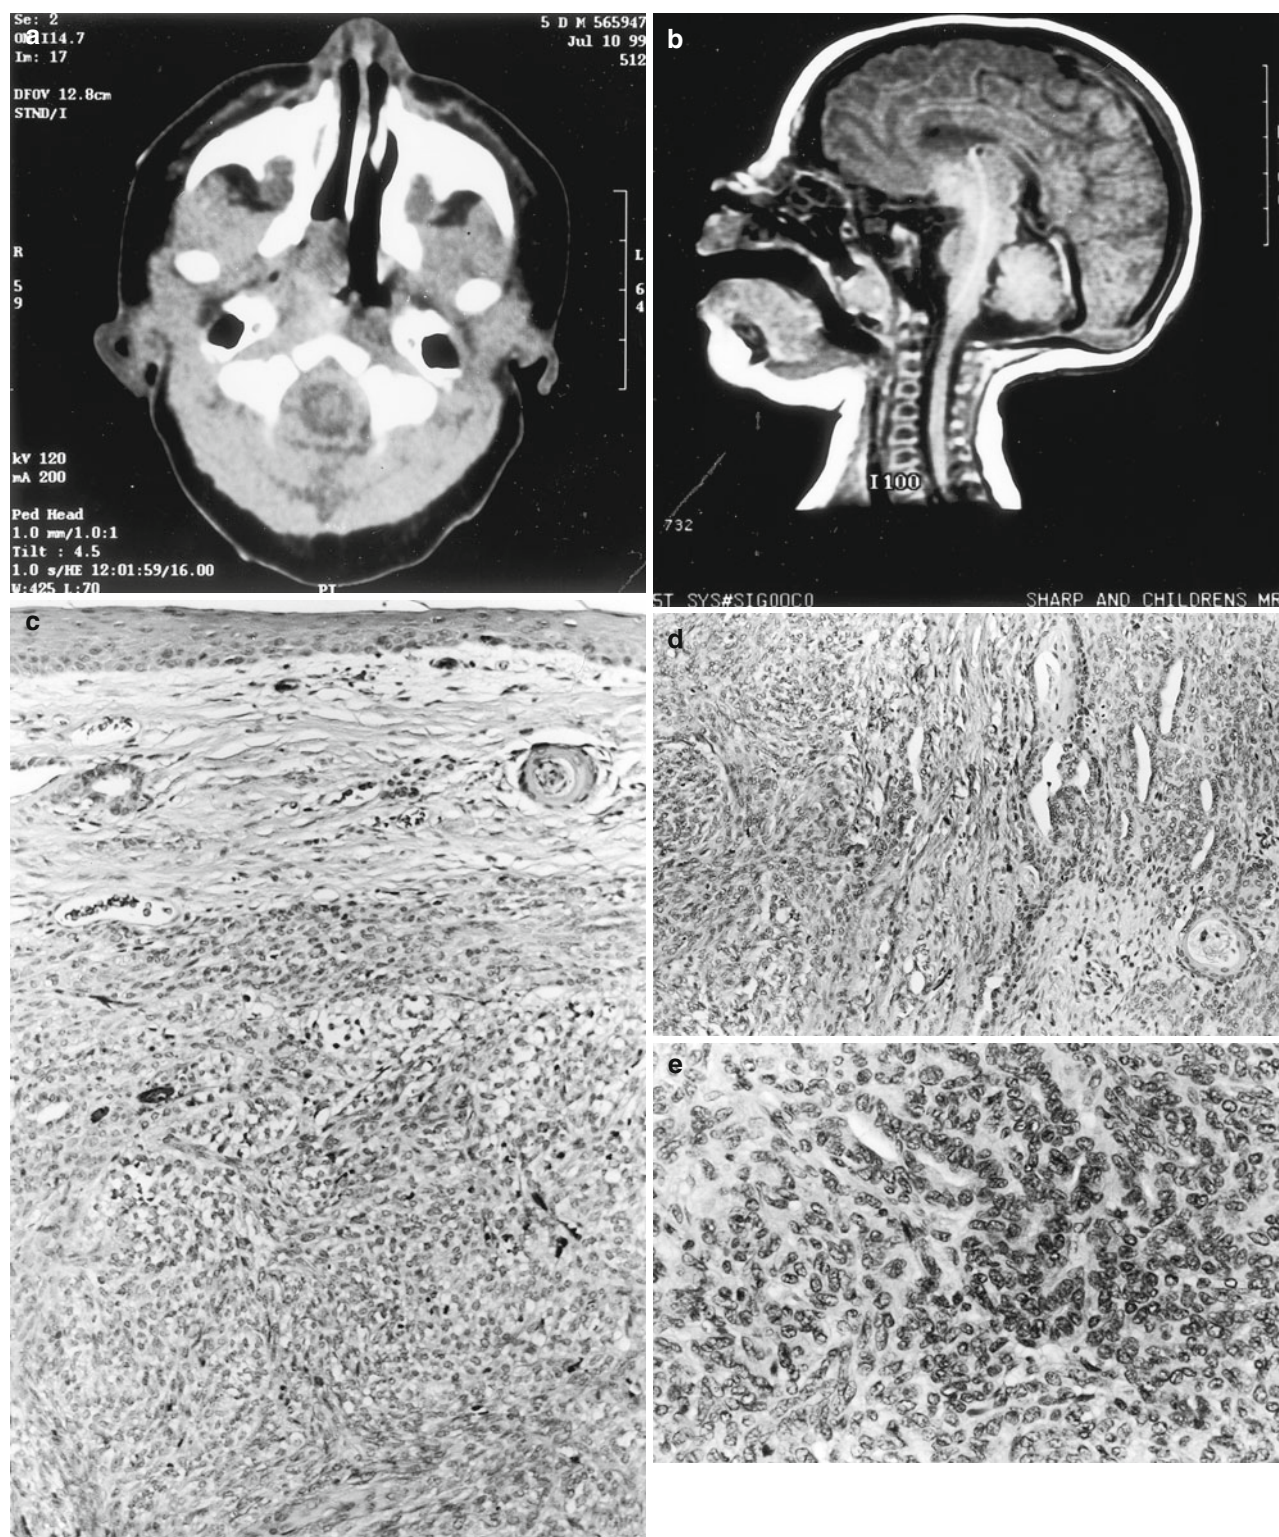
Pleomorphic adenoma (salivary gland anlage tumor). Ten-day-old male with respiratory and feeding difficulties since birth. (a) CT axial scan through the skull base without contrast reveals a nasopharyngeal mass of soft tissue density extending from the nasal choanae to the retropharyngeal soft tissues. (b) MRI shows a 2×1.4×1.3-cm, pedunculated, enhancing, soft tissue mass within the nasopharynx (c) low magnification revealing an intact, nonkeratinized, stratified squamous epithelial mucosa on the top, hypocellular submucosa containing a duct-like structure and a round nest of squamous cells. (d)
